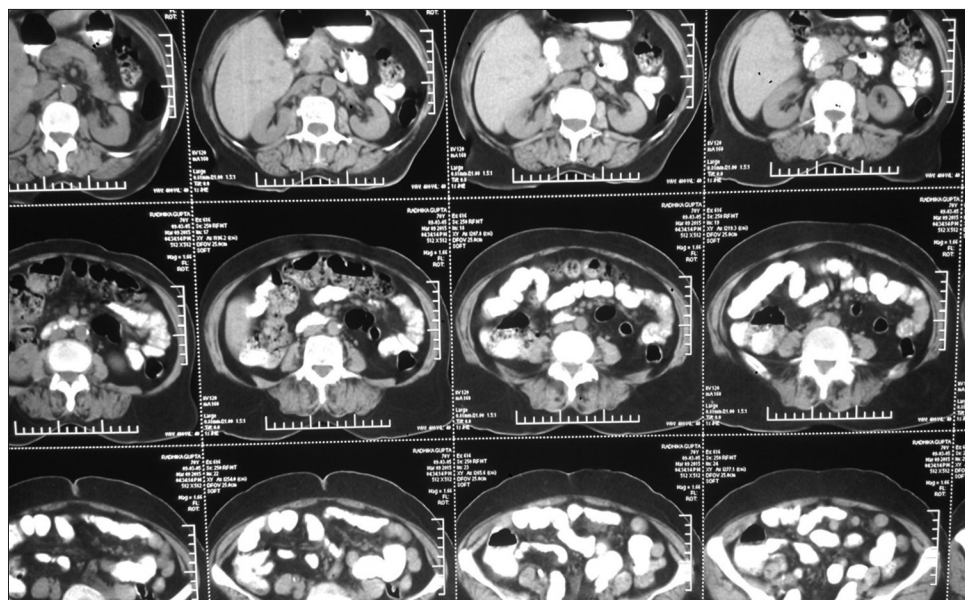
Computed tomography scan abdomen showing left adrenal adenoma
